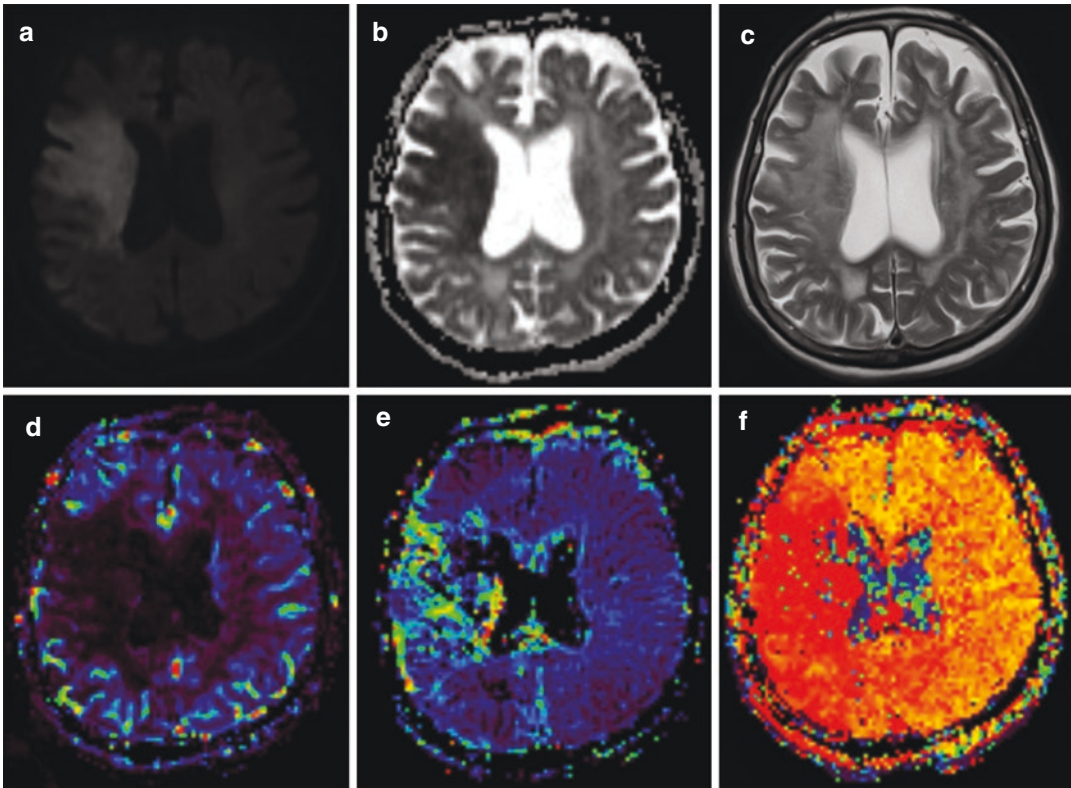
DWI, ADC, and MR perfusion maps of a patient with right MCA stroke: (a and b). DWI image shows diffusion restriction in the right frontal lobe, (c) T2-weighted image demonstrates cortical swelling and edema in the diffusion-restricted area in right frontal lobe, (d) CBV map shows decreased blood volume in the right frontal
